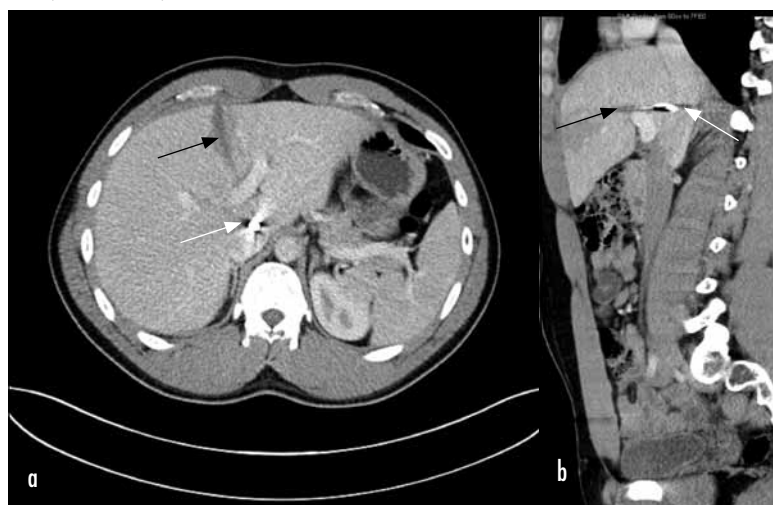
a. Transverse and (b) sagittal abdominal computed tomography scan of a male patient shot at 'point blank' range with an air rifle. Note the air pellet in situ (white arrow), causing slight indentation of the inferior vena cava. Also note missile tract to skin (black arrow).
